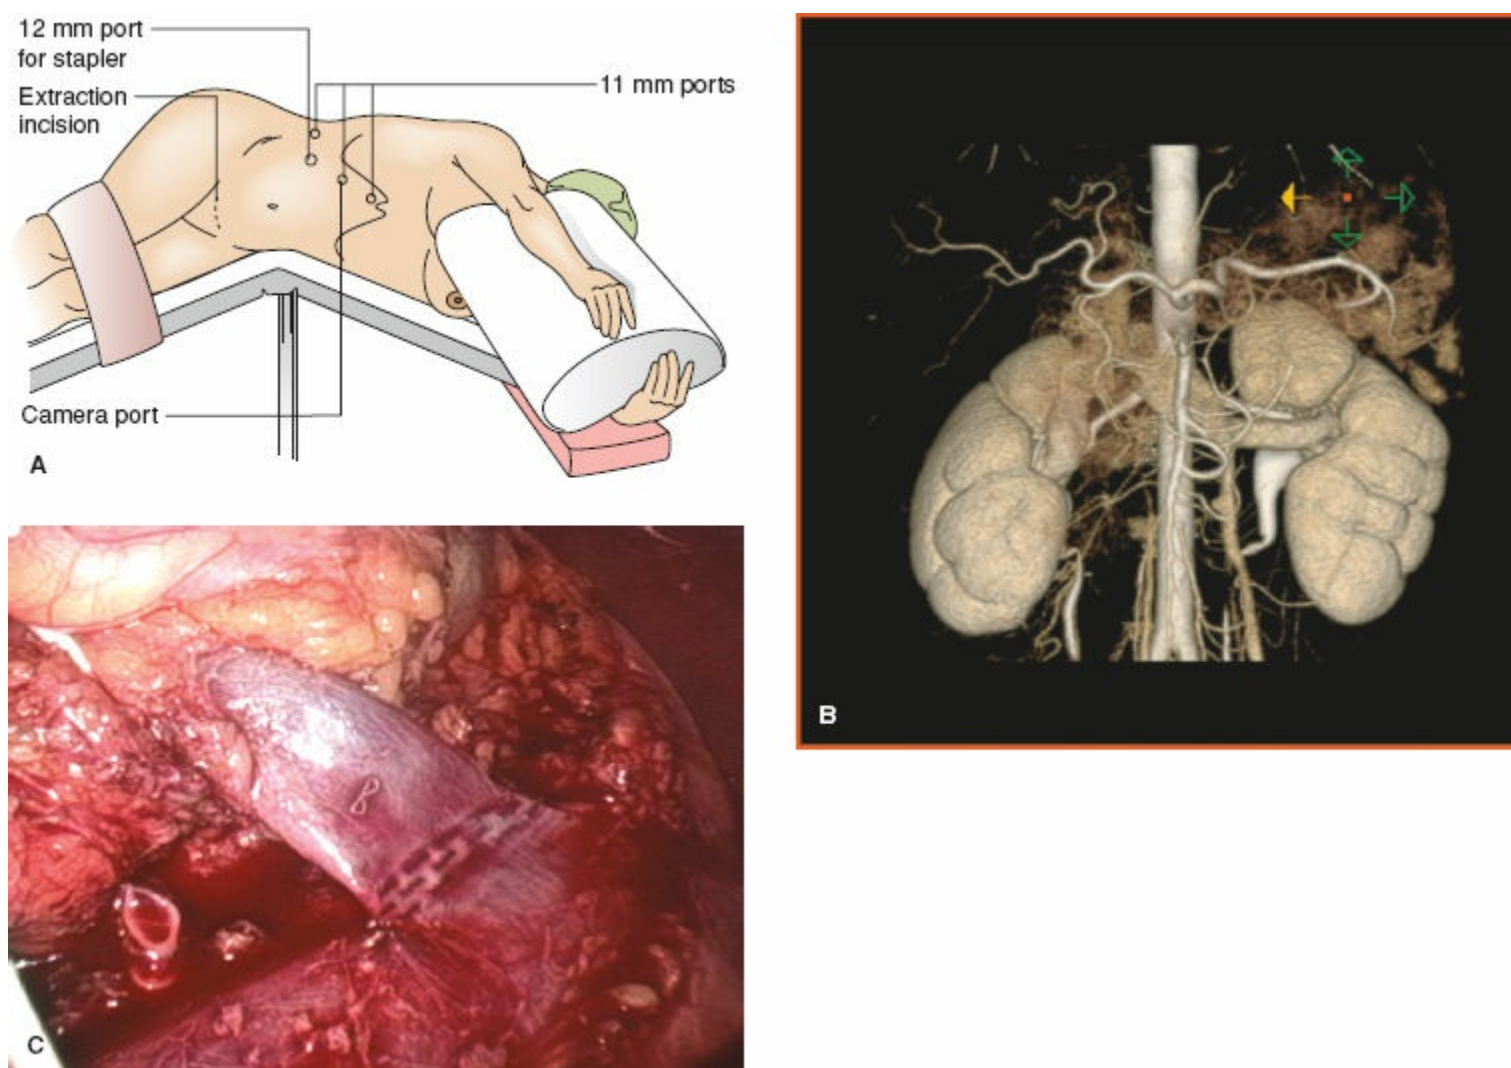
A: The laparoscopic donor procedure is performed with the donor in a lateral position, typically using three to four ports, with extraction of the kidney through a 6- to 8-cm incision. B: Preoperative computed tomography angiogram revealing the arterial and venous anatomy. C: Intraoperative photograph of laparoscopic view of right kidney just prior to transection of the renal vein. The artery has already been divided.
